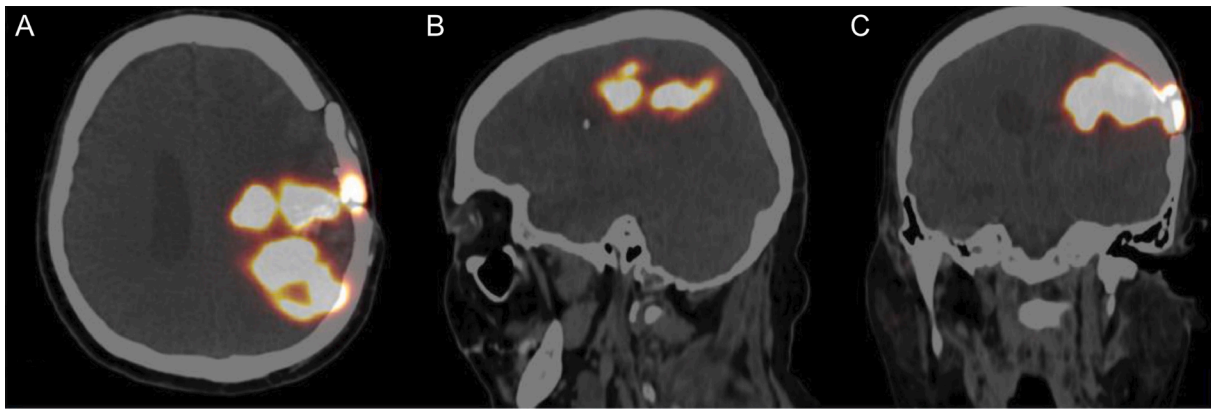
Axial (A), sagittal (B) and coronal (C) PET/CT images obtained after local co-injection of 10 MBq ^{68}Ga -DOTA labelled Substance P (SP) with a therapeutic dose of ^{225}Ac -DOTAGA-SP into the resection cavity of a GBM, demonstrating that the activity is concentrated within the lesion. Adapted with permission from: L. Króllicki et al. [156]
